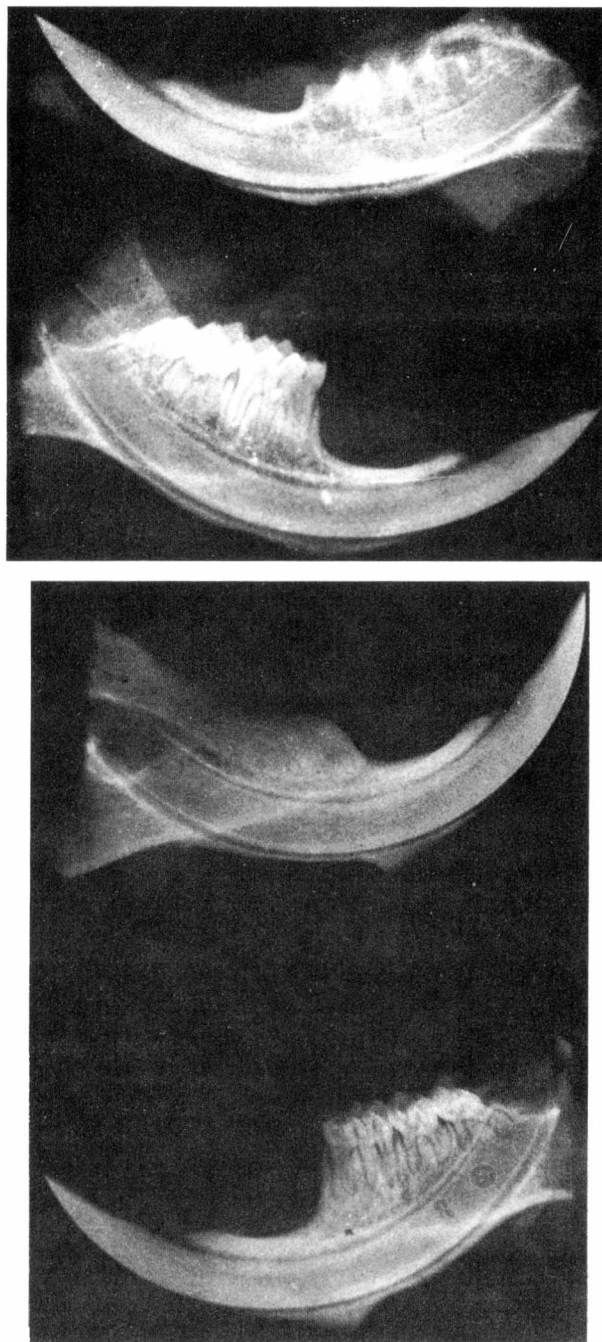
(above). Radiographic image immediately after surgery. *Upper*, Edentate ridge. Notice radiopaque line defining the sockets. *Lower*, Dentate ridge.
